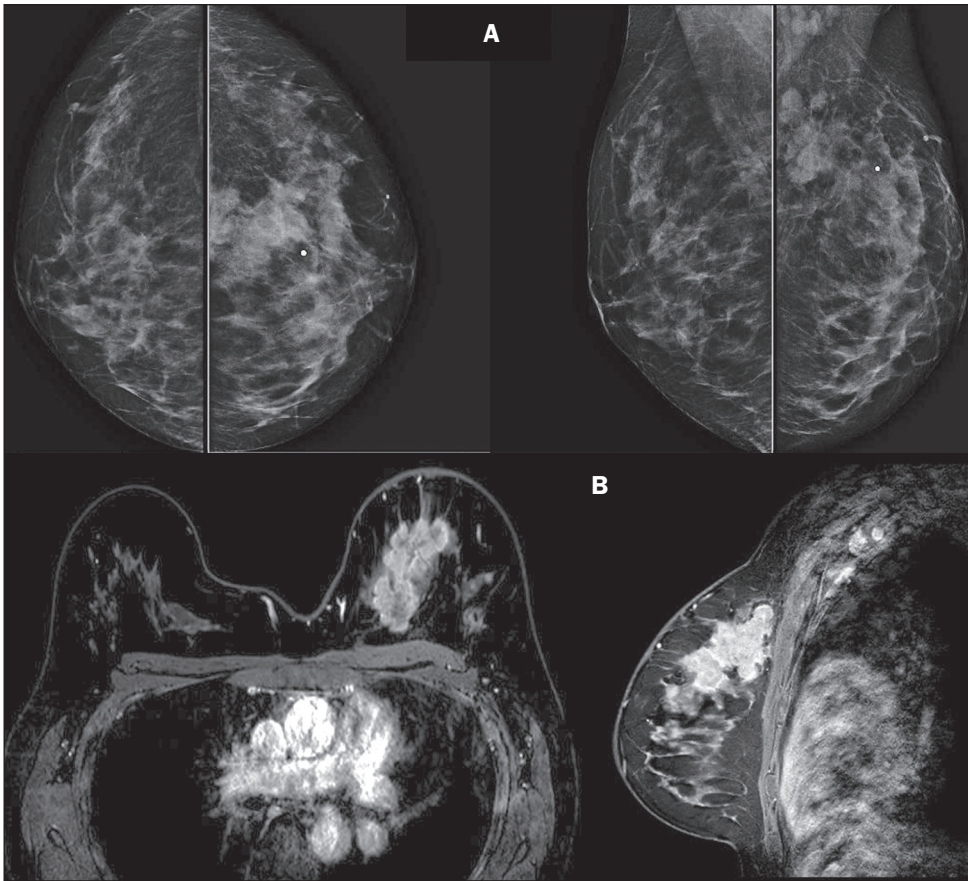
A 30-year-old patient who had undergone mantle-field (thoracic) radiotherapy for the treatment of HL at 11 years of age and did not undergo subsequent screening, presenting with a palpable mass in the left breast. A: Diagnostic mammography showing an irregular mass in the posterior third of the junction of the upper quadrants of the left breast, measuring 6.0 cm, accompanied by architectural distortion and calcifications, together with atypical ipsilateral axillary lymph nodes, classified according to the BIRADS as a category 5 (probably malignant) finding. B: Breast MRI confirming the irregular mass occupying the upper inner quadrant of the left breast, measuring 7.8 cm. Biopsy confirmed a diagnosis of invasive ductal carcinoma, categorized as the luminal B subtype with overexpression of human epidermal growth factor receptor 2. A positron-emission tomography/computed tomography scan, performed for staging, showed lung metastases (clinical staging, T3N2M1).
